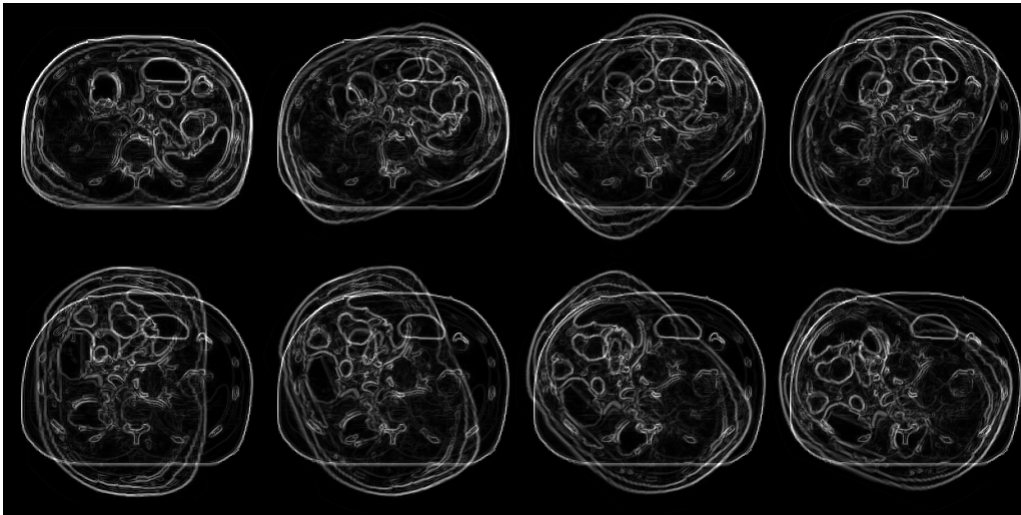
Angle between overlaid CT and MRI image gradients varying from 0° to 160° ; note that when the angle is 0° , the two images are very well aligned.
